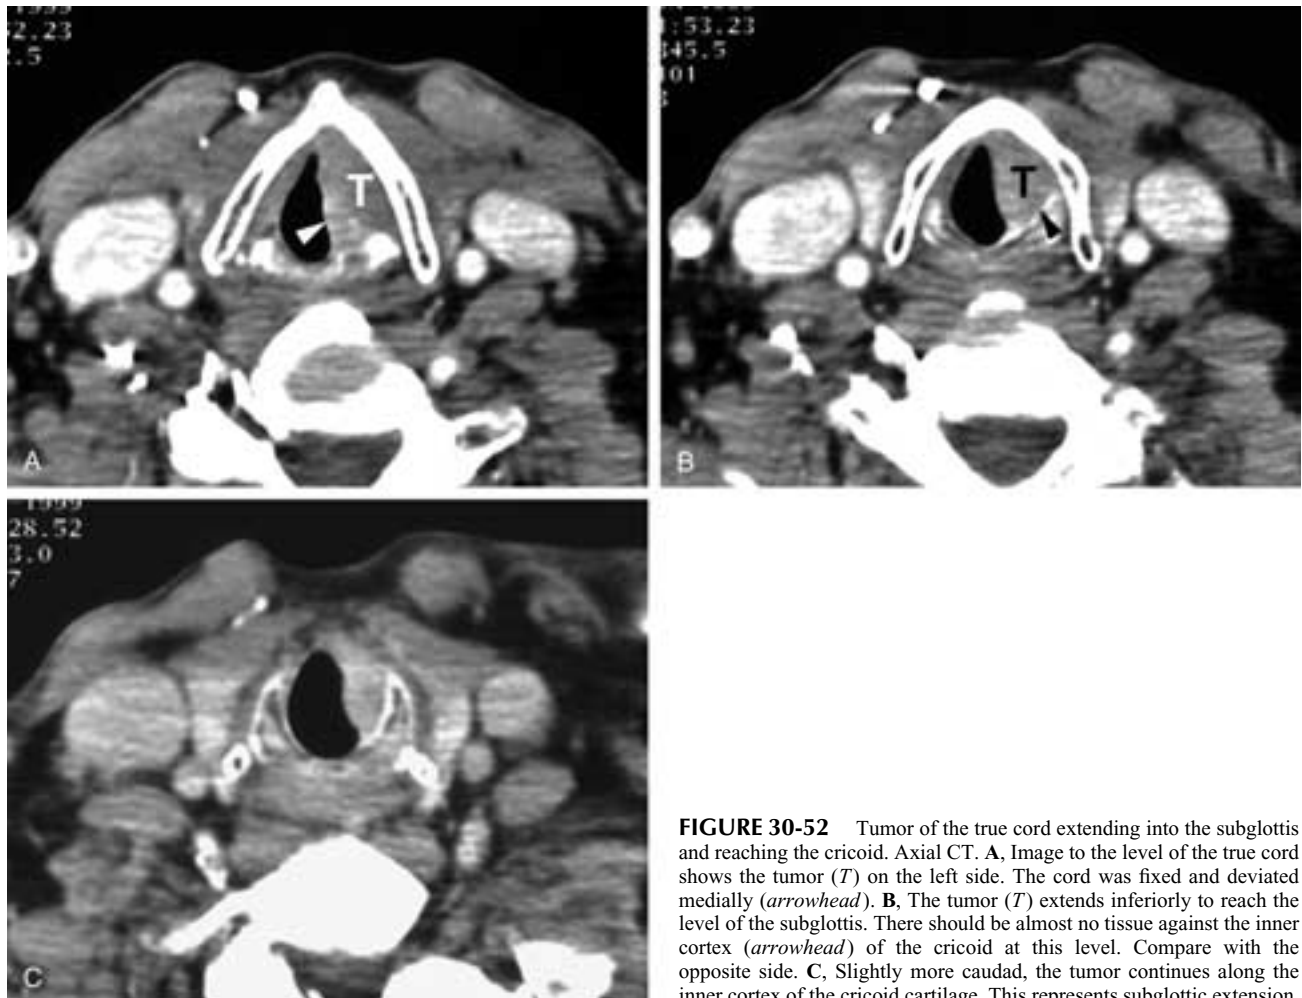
Tumor of the true cord extending into the subglottis and reaching the cricoid. Axial CT. A, Image to the level of the true cord shows the tumor (*T*) on the left side. The cord was fixed and deviated medially (*arrowhead*). B, The tumor (*T*) extends inferiorly to reach the level of the subglottis. There should be almost no tissue against the inner cortex (*arrowhead*) of the cricoid at this level. Compare with the opposite side. C, Slightly more caudad, the tumor continues along the inner cortex of the cricoid cartilage. This represents subglottic extension.
